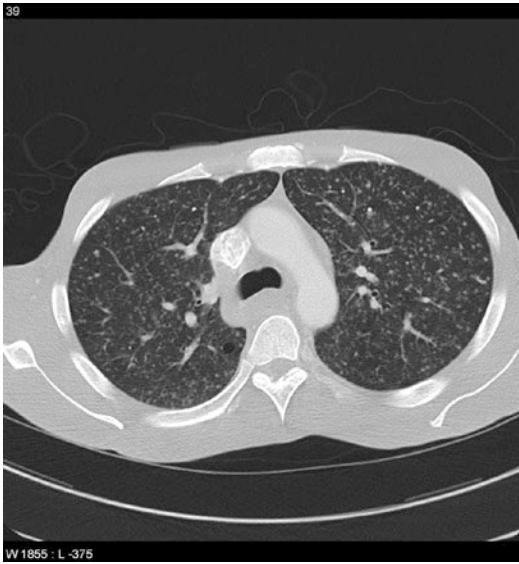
A 52-year-old HIV-positive male with miliary tuberculosis: axial CT showing multiple well-defined nodules in a random distribution much better
